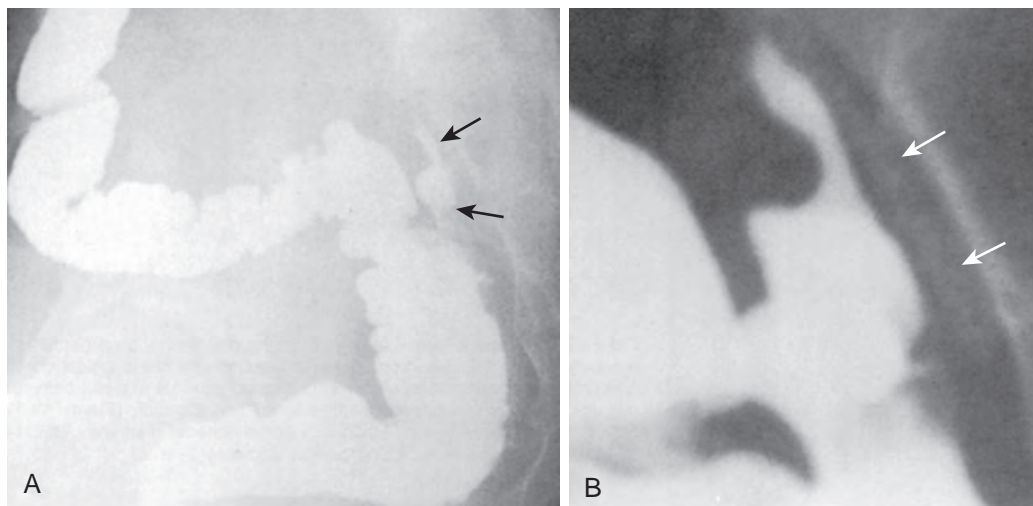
Pseudoleakage. This appearance is commonly seen with a J-pouch reservoir in which there is incomplete filling of the J-pouch appendage and represents a potential radiographic pitfall. A. Traces of contrast material (arrows) appear to extravasate from the proximal posterior part of the J-pouch reservoir. B. Additional spot image with further distention shows contrast material surrounded by a faintly visible suture line (arrows) just anterior to the sacrum. The lateral view also demonstrates the anterior position of the lower portion of the pouch, which traps air in the supine position, impairing visualization of the J pouch–anal anastomosis. (From Kremers PW, Scholz FJ, Schoetz DJ Jr, et al: *Radiology of the ileoanal reservoir*. AJR 145:559–567, 1985.)
